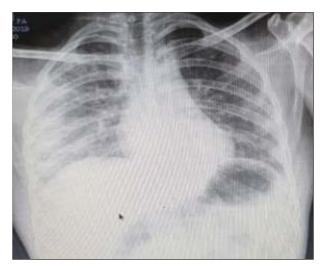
Chest X-ray suggestive of Pulmonary opacities in a paraquat poisoning patient taken at the time of admission, 3 days post consumption.
